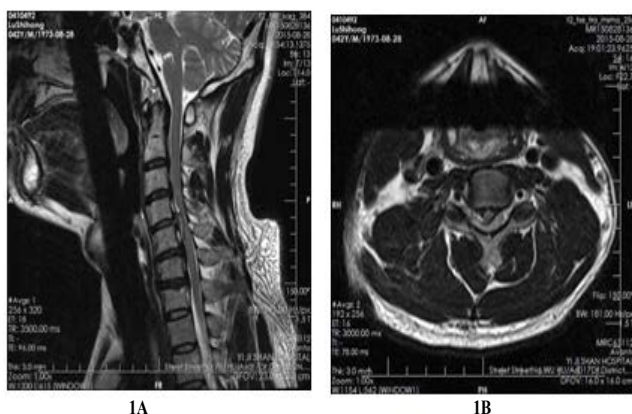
Preoperative T2-weighted sagittal (A) and axial (B) MRI revealed a larger right paramedian C4/5 disc herniation and severe compression of the ipsilateral spinal cord.
